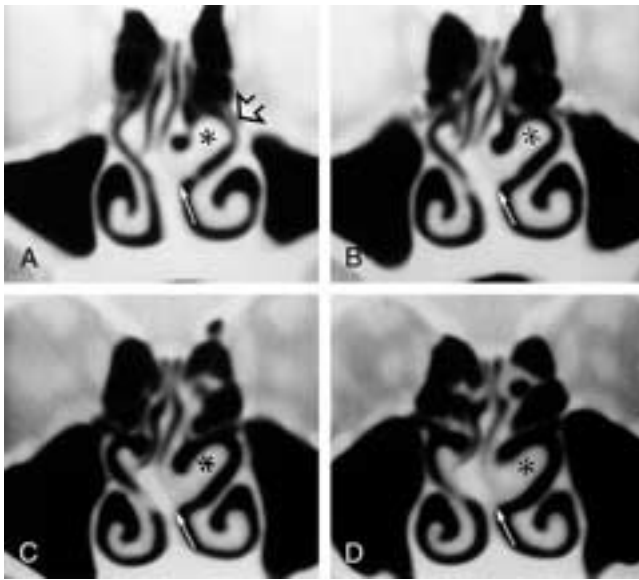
Coronal CT scans. A to D, The free edge of the middle turbinate may also assume some other shapes. Note its prominent lateral curvature in this case (*asterisk*). It obstructs the nasal passage (*fine white arrows*) and contributes to the position of the uncinate process and, therefore, the prominent narrowing of the infundibulum (*open arrow*).
